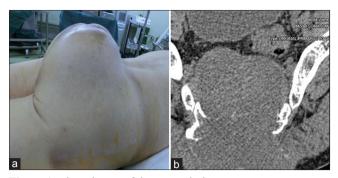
a is an image of the tumor during our assessment preoperatively while b; is a pre-operative CT-Scan
